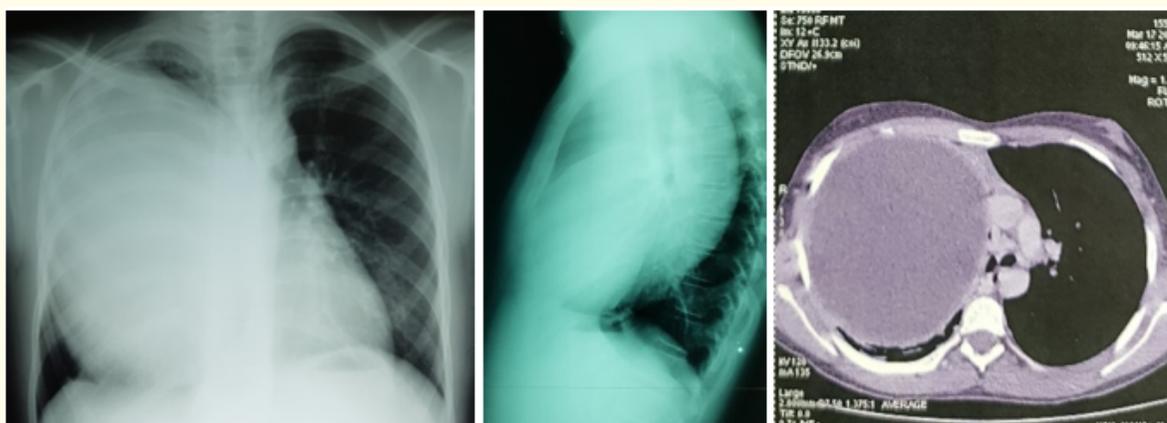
Preoperative chest x-ray with CT scan of right pulmonary hydatid cyst in 14 years old boy (17cm).
